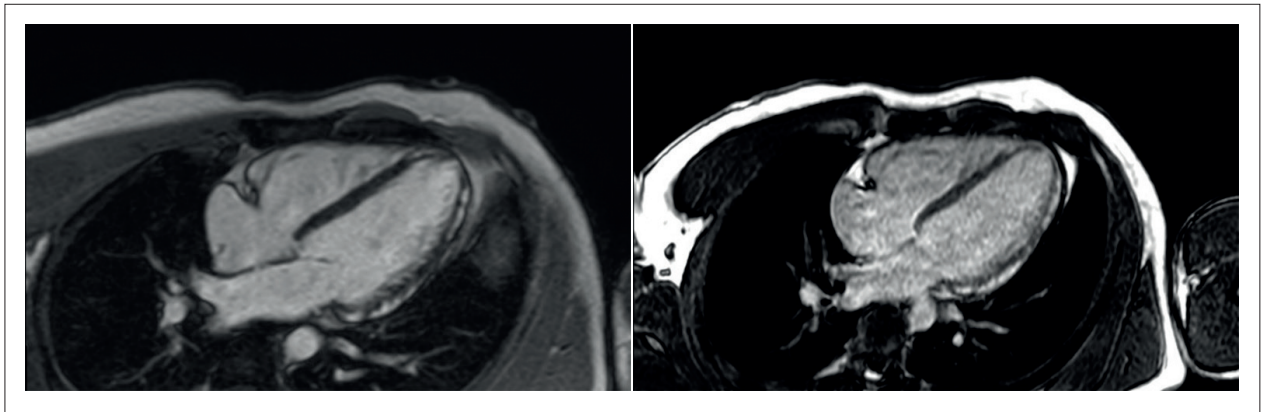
Cardiac magnetic resonance imaging showing late enhancement. Image 1: first exam; image 2: exam performed 48 hours later.
